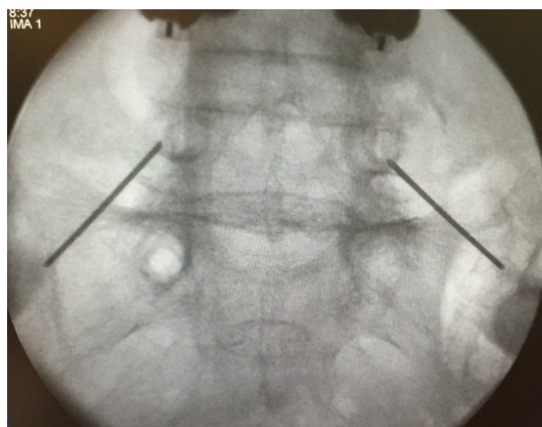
Entry point of the trocar at the inferior-lateral border of the X-ray pedicle appearance.
